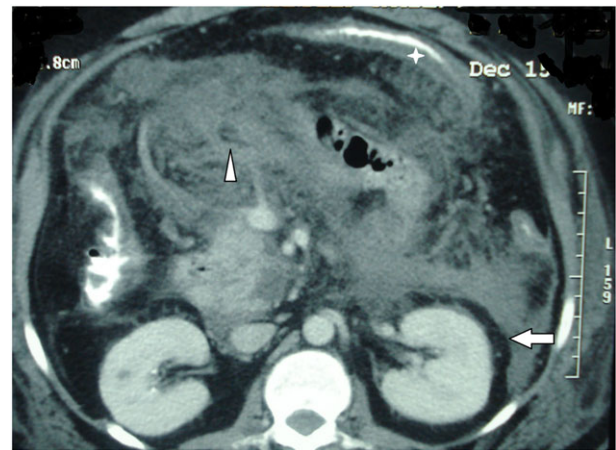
Extra-pancreatic computed tomography changes: abdominal computed tomography showing renal rim grade 2 (arrow), mesenteric edema (arrowhead), and mural thickening of colon (star).
